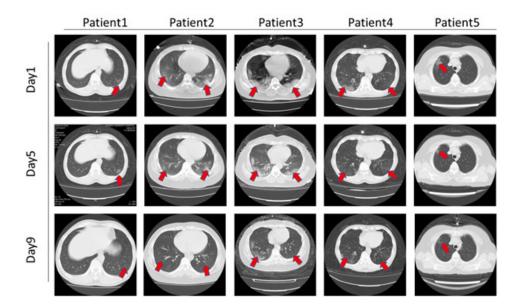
Chest CT scans of the five Covid-19 patients during their hospitalization. On admission day 1, a single lung or both lungs showed multiple groundglass opacities changes (arrows). On days 5 and 9, the pathological changes in the lungs were gradually absorbed.
